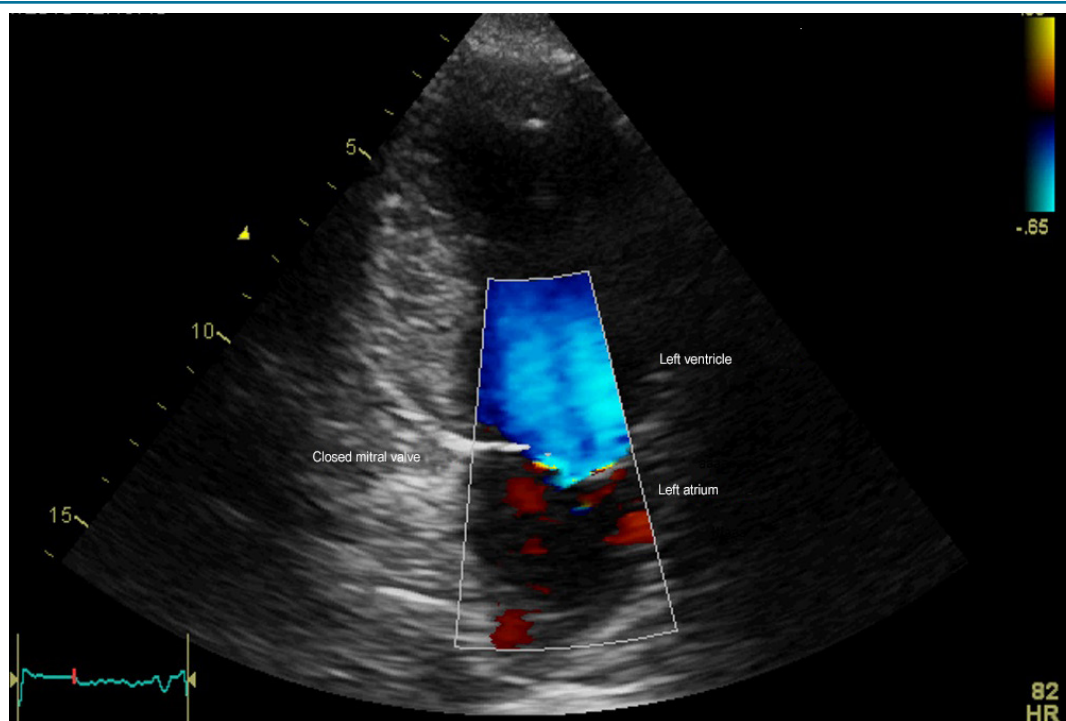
Color echocardiogram performed one week after the first examination showing the disappearance of the regurgitant jet.
